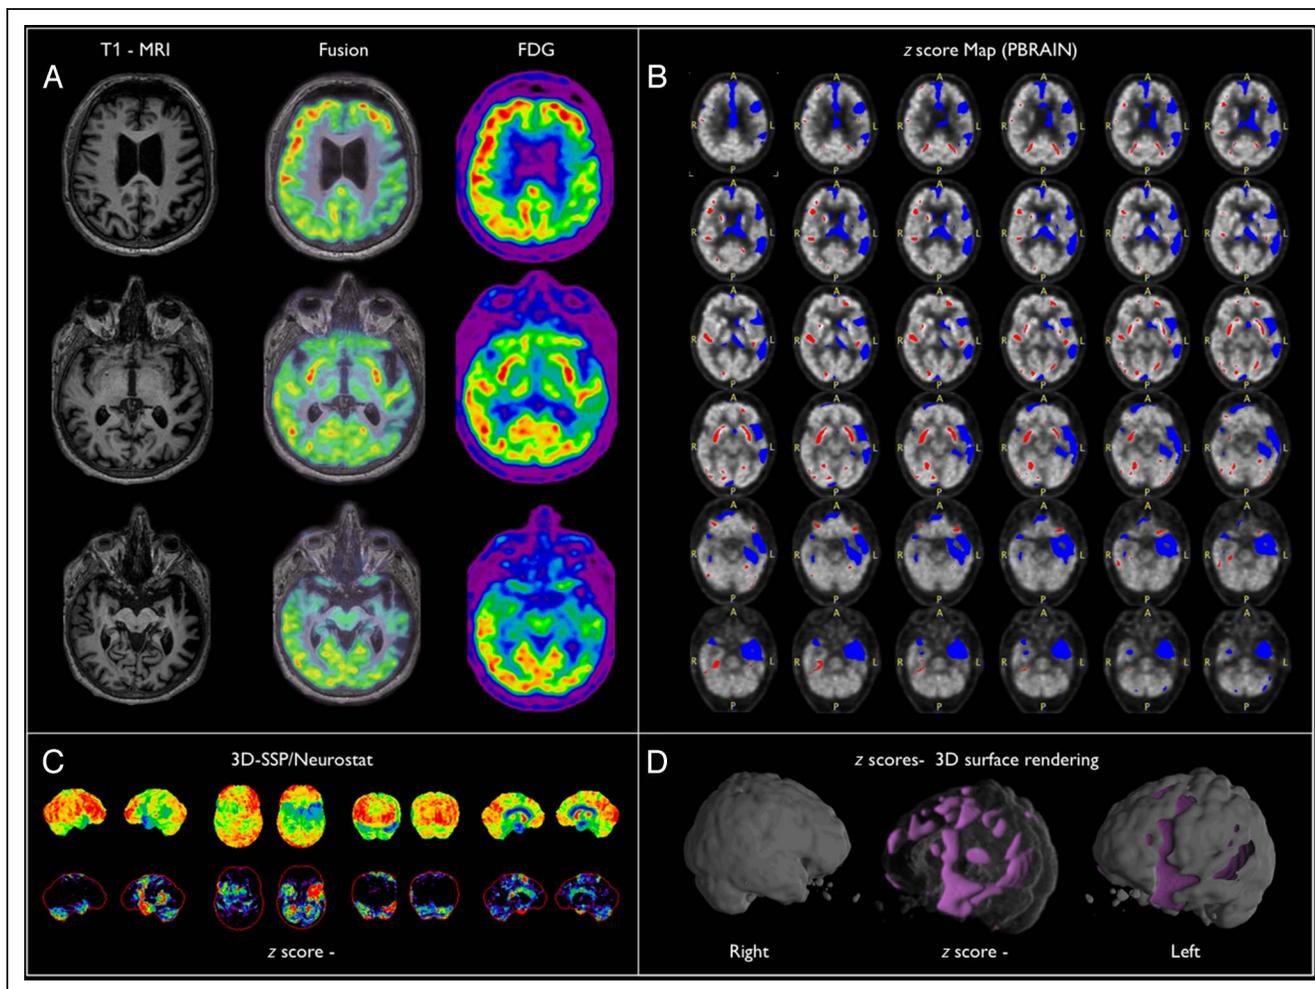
(A) Coregistration of the FDG PET acquisition in C.M. with the 3-D MRI. (B) Map distribution of the negative (blue) or positive (red) z scores comparing C.M. with healthy participants, surimposed to the FDG distribution. (C and D) 3-D volume rendering of the z-score deficits distribution generated with neurostat/ED-SSP software (C) and with PMOD module (D).
